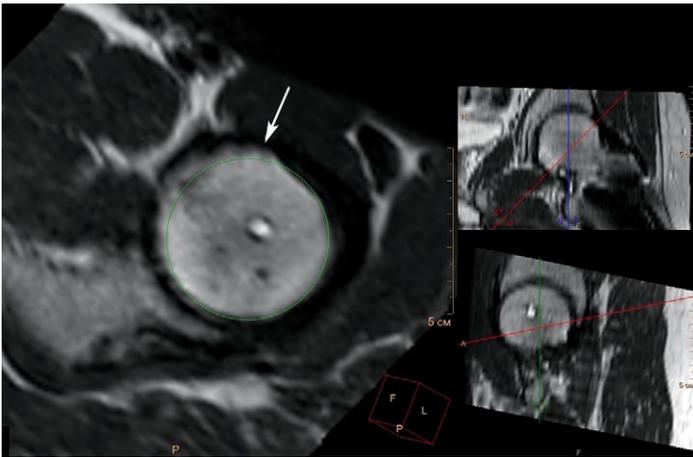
MRI of the left hip (radial section at the level of head-neck junction perpendicular to the femoral neck axis, T2 weighted image) of patient 18 years 7 months old; 5 years 2 months after surgery: deformation of head-neck junction (indicated by an arrow)— excess bone mass in the anterior-superior part of the transition, which damages sphericity of the femoral head
